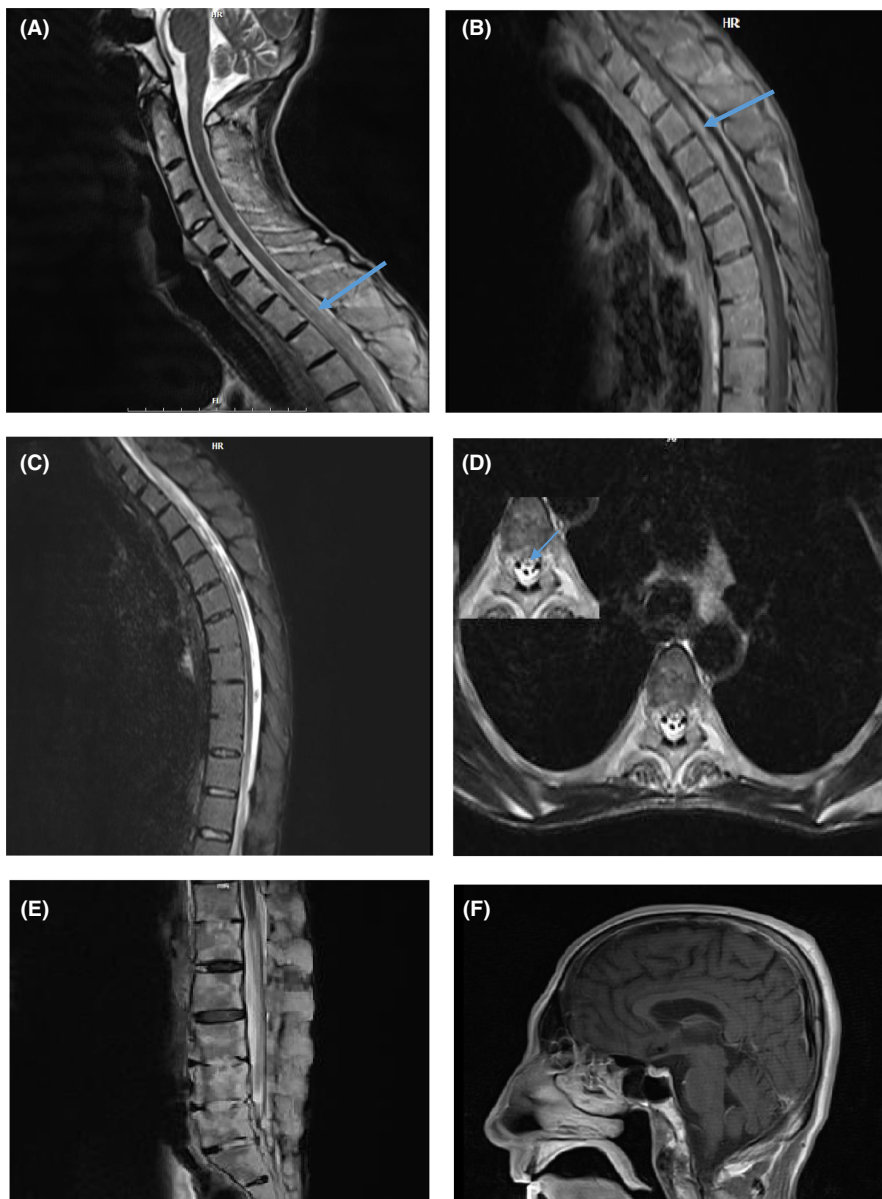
(A) Sagittal view cervical MRI without GAD (T2) (B) Sagittal view thoracic MRI with gadolinium (T1) demonstrates long lesion with enhancement in the thoracic cord from cervicothoracic junction to T12. (C) Sagittal view thoracic MRI (STIR) with gadolinium (D) Axial view thoracic MRI demonstrates “Owl eye” sign in central cord. (E) Sagittal view lumbar MRI (T1) showed incomplete fusion in lumbar vertebrae, which caused loss of lordosis. (F) Axial view brain MRI with gadolinium (T1) without evidence of pathologic lesion.
